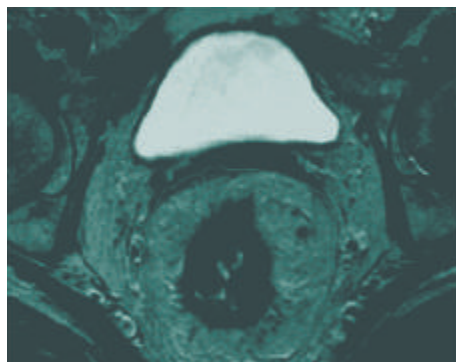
MRI of rectal cancer. Mesorectal fascia outlined in red
